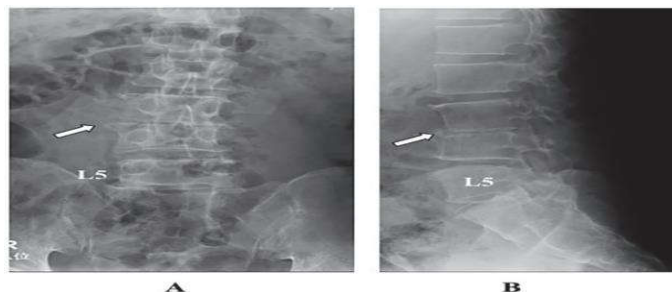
Plain radiograph findings of pyogenic spondylitis due to *Streptococcus pneumoniae* in 59-year-old man.
